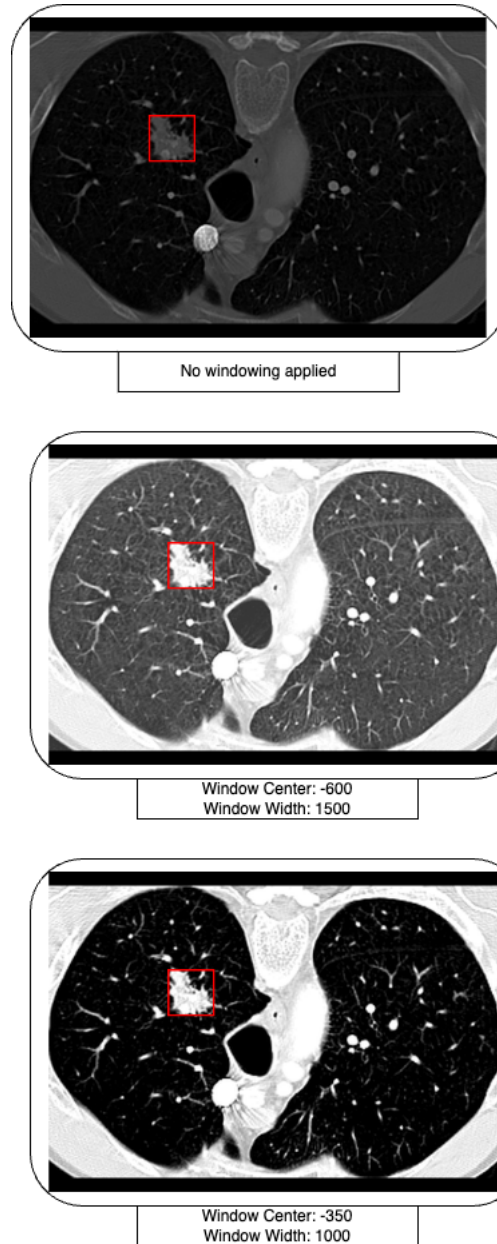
Effect of windowing parameters on CT image visualization. Each panel represents a CT image processed with different windowing configurations: Top: No windowing applied; Middle: Window Center  $-600$  HU, Window Width  $1500$  HU, emphasizing lung tissues; Bottom: Window Center  $-350$  HU, Window Width  $1000$  HU. The red bounding box highlights the lung nodule, demonstrating how different windowing settings enhance or obscure the visibility of nodules and surrounding tissues.
